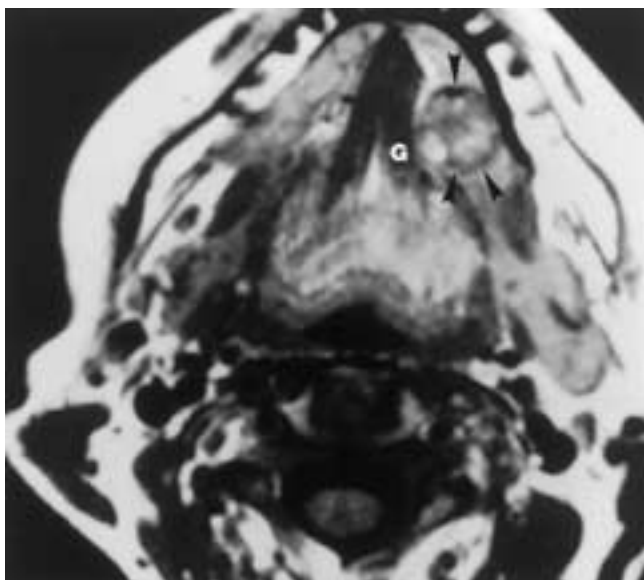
Mucoepidermoid carcinoma of the left sublingual gland. Axial T1-weighted MR image demonstrates a fairly well circumscribed heterogeneous lesion centered within the left sublingual space (*arrowheads*). The lingual aspect of the adjacent mandibular cortex appears intact, as does the lateral margin of the left genioglossus muscle (*G*).
